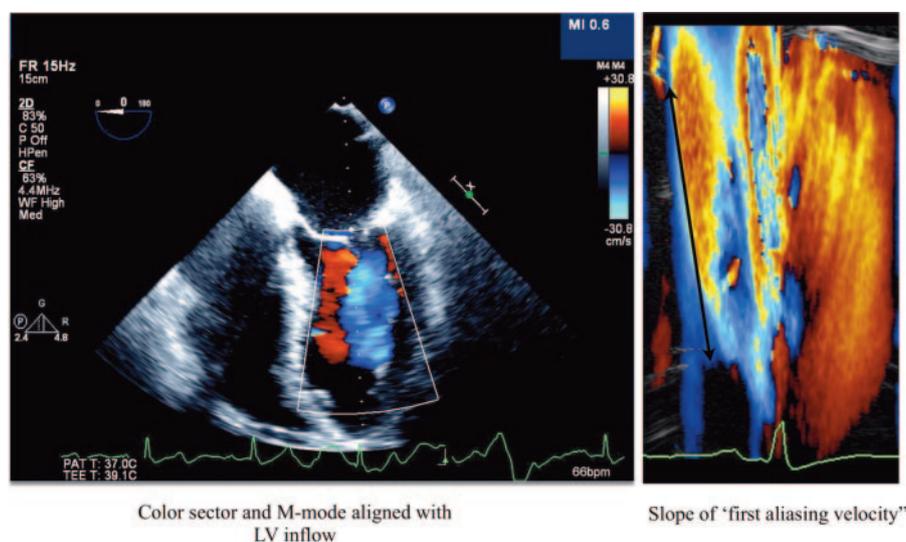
Transmittal flow propagation velocity. Left panel, Midesophageal 4-chamber view with color flow Doppler sector and M-mode cursor aligned with the left ventricular (LV) inflow. Right panel, Measurement of the transmittal flow propagation velocity.
